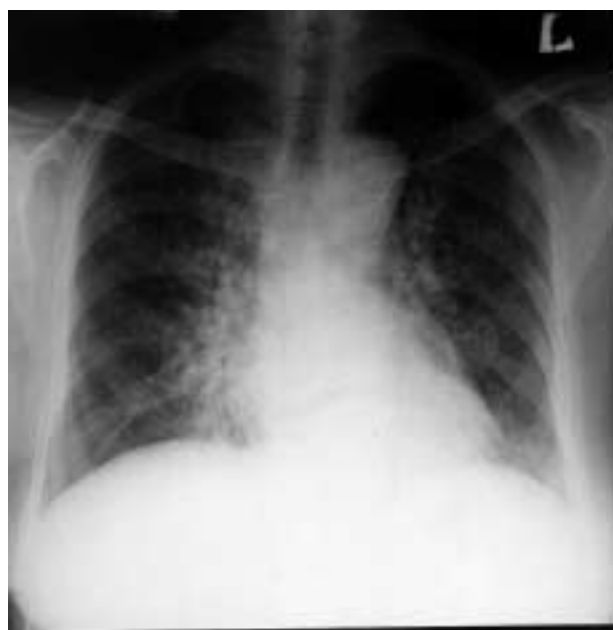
Chest radiograph on presentation; showing diffuse mottlings of both lungs highly suggestive of miliary tuberculosis.
